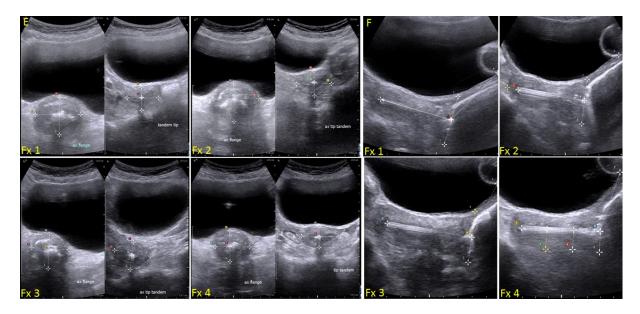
Interfraction ultrasound verification
